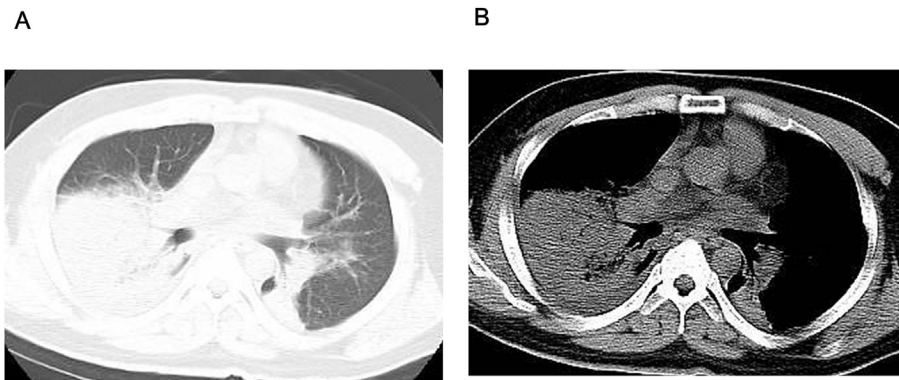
Chest computed tomography scan on admission reveals airspace consolidations with air bronchograms in the lower lobes and right middle lobes (lung window) (A). These consolidations are of the same densities as those of the muscle and heart in the mediastinal window (B).
